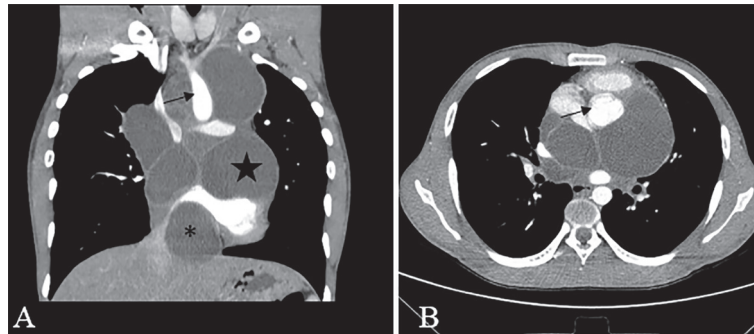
This figure demonstrates mediastinal hydatid disease in a 36-year-old man with persistent fever, cough, weight loss, and dyspnea. Chest radiography showed both mediastinal widening and multiple lobulated mediastinal opacities. A. Coronal contrast-enhanced CT scan of the chest shows several cysts of various sizes within the mediastinum as well as encasement of mediastinal vessels without evidence of thrombosis (arrow). Simple-appearing cysts are also noted within the heart at the junction of the IVC and right atrium (asterisk), as well as the atrioventricular junction (star). B. Axial CT scan of the same patient at the carina level indicates multiple mediastinal cysts pushing the aorta anteriorly (arrow) and causing severe vascular encasement. After three months of medical treatment with antihelminthic medication, the patient's symptoms improved, and a significant decrease in the size of the cysts was observed. This figure was obtained from a patient who was admitted to the authors' institution and was not previously published elsewhere.
